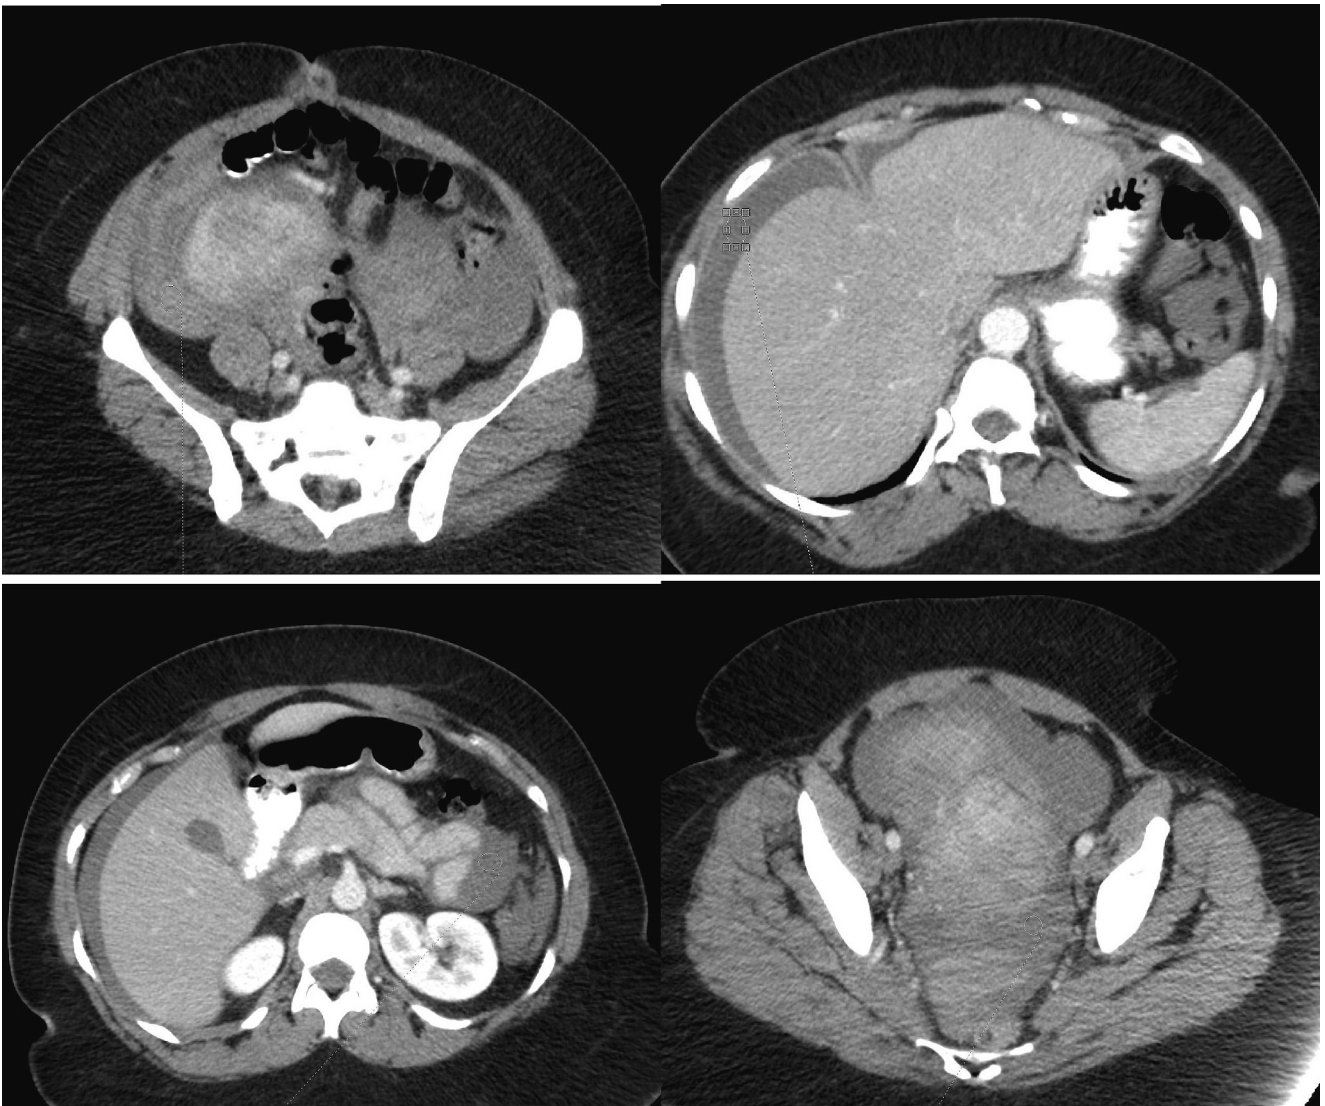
CT images show significant hemoperitoneum. The sentinel clot sign, a finding of hyperdense fluid collection adjacent to the bleeding organ, is best seen in the top-left image. Fluid near the liver, intestines, and pelvis is not as dense as it is near subserosal fibroid.
